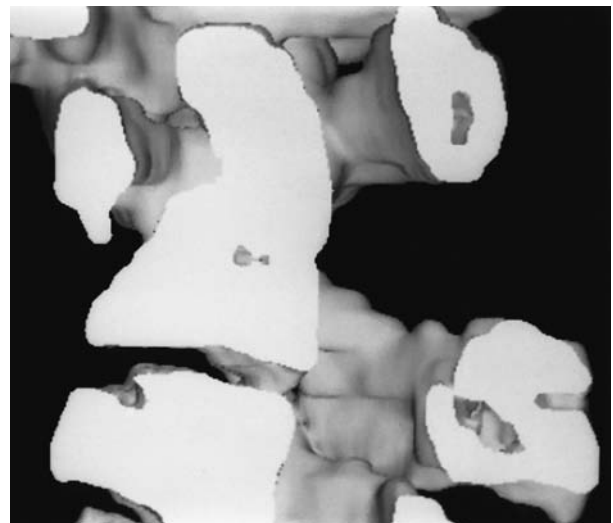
A: Midsagittal T_1 -weighted MR image of the craniocervical junction in a 10-year-old boy with fixed atlantoaxial dislocation causing severe ventral cervicomedullary compression. B: Three-dimensional CT scan of the upper cervical spine and craniocervical junction with midsagittal visualization of the fixed atlantoaxial dislocation and severe compromise of the spinal canal.
